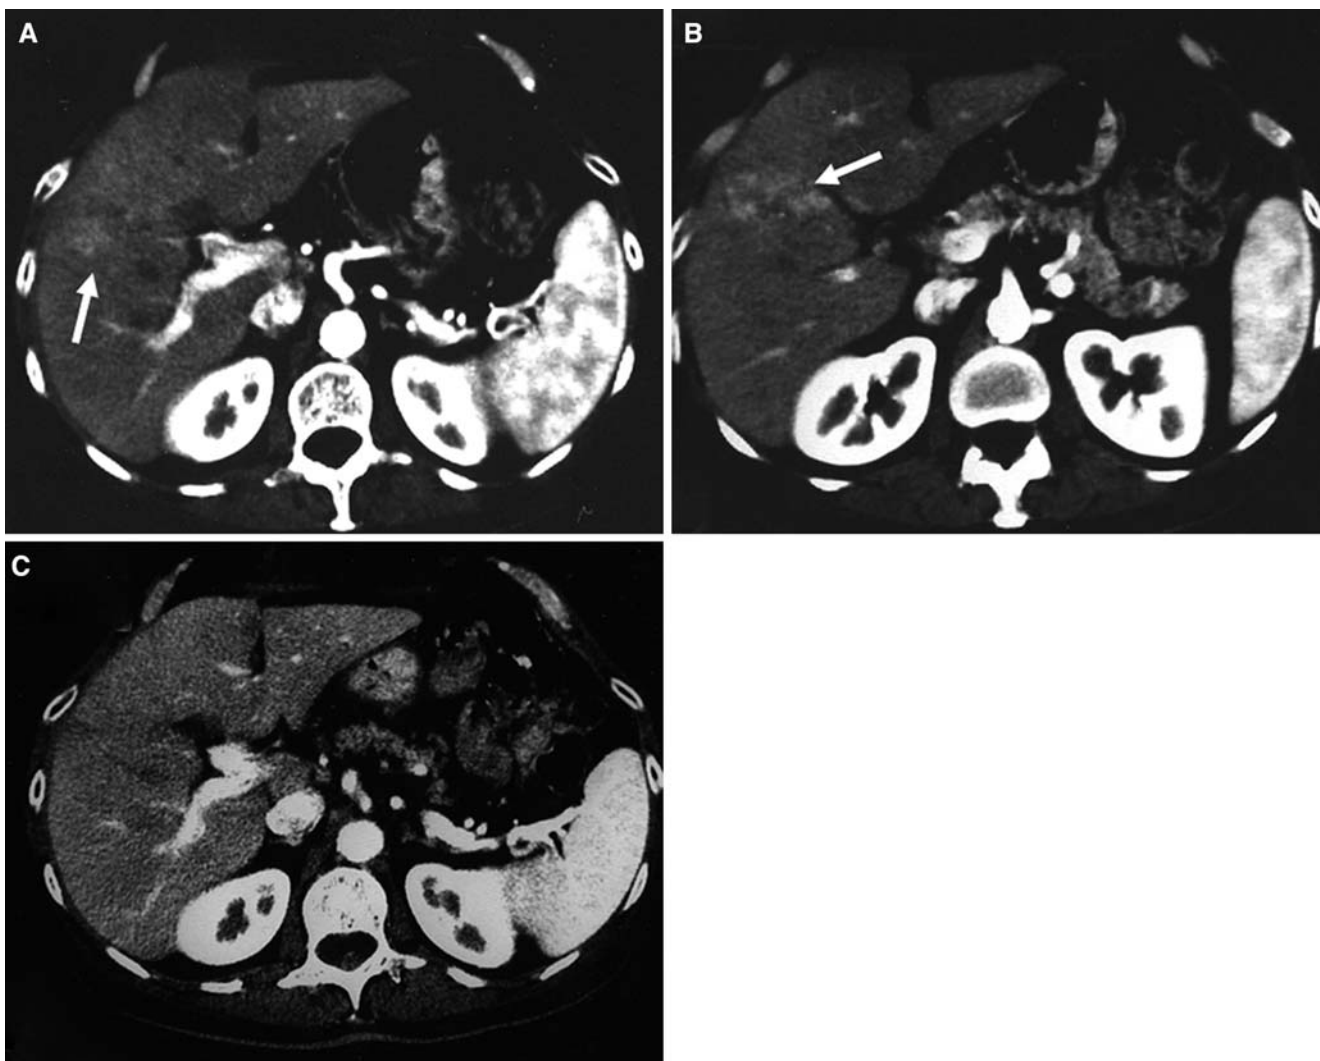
A 64-year-old man with cholangitis. (A), (B) CT artery phase shows polymorphous THADs (*arrows*) without dilation of biliary vessels. (C) Three months later, after therapy, at artery phase CT, the arterial phenomena disappeared.
